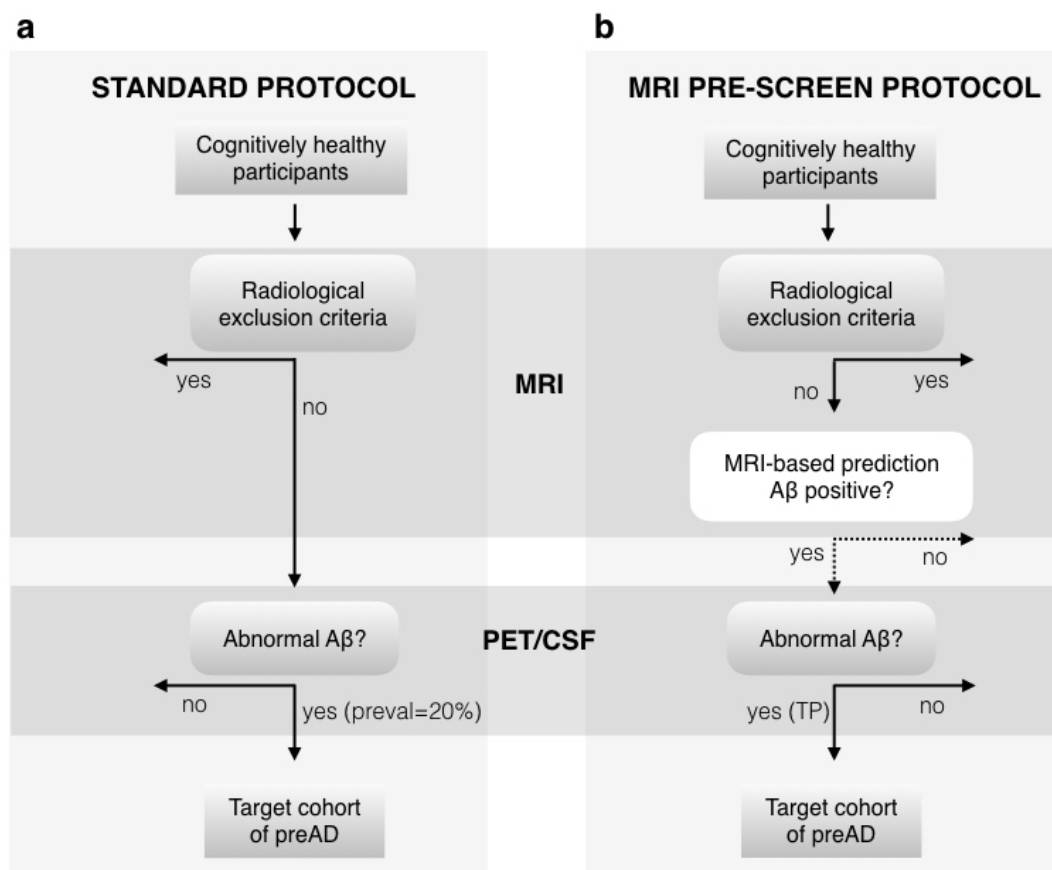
Outline of clinical recruitment protocol of subjects with preclinical (PC) Alzheimer’s pathology. (a) Standard recruitment protocol used in clinical trials. (b) Our proposed protocol with MRI-based machine learning. In the standard protocol, cognitively unimpaired participants undergo an MRI scan to identify radiological exclusion criteria (e.g. cerebrovascular disease). All cognitively unimpaired subjects with no brain injuries then participate in a PET/CSF test, and the fraction of $A\beta$ positives is determined only by the disease prevalence. The proposed protocol adds an exclusion layer in which automated MRI-based classification predicts a subset of amyloid positive subjects that are later subjected to PET/CSF acquisition. In this case, the target cohort is defined by the true positive rate ($TP\%$) of the classification algorithm. The initial participant pool needs to be larger for the proposed protocol due to classifier false negatives that may be excluded.
